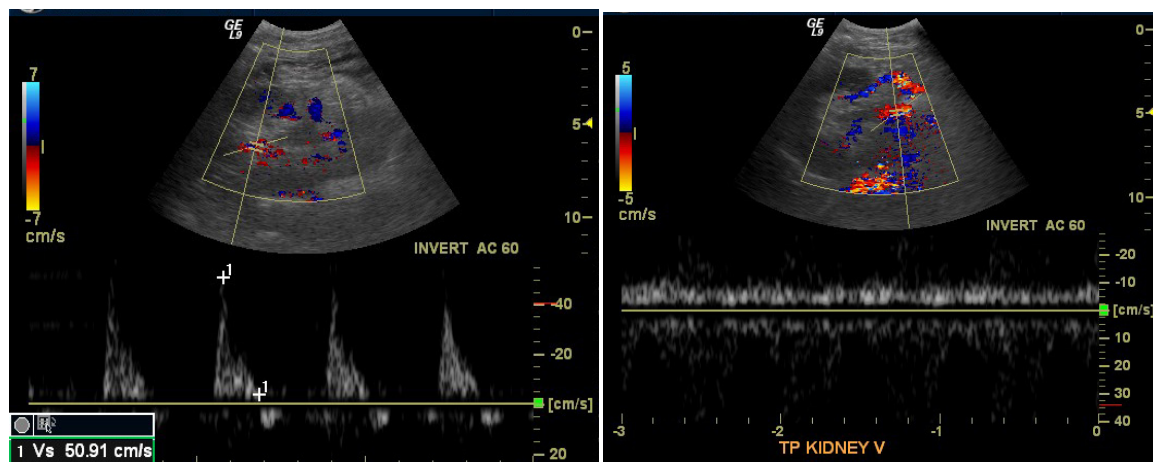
A and B: Severe acute rejection. Image A, a color Doppler and spectral waveform US image through the intrarenal artery close to the hilum demonstrates early diastolic flow reversal suggestive of severely increased resistance. Image B, a Doppler image through the renal vein shows a patent renal vein.
